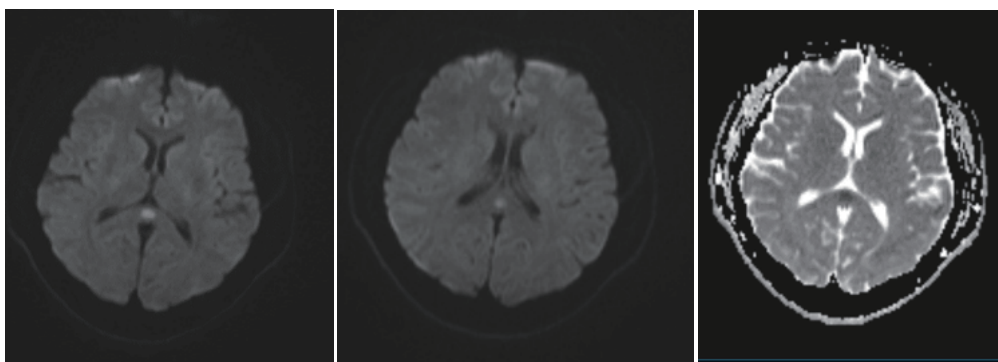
A hyperintense lesion in the splenium part of the corpus callosum in the MRI diffusion is observed in the ADC in case 3
